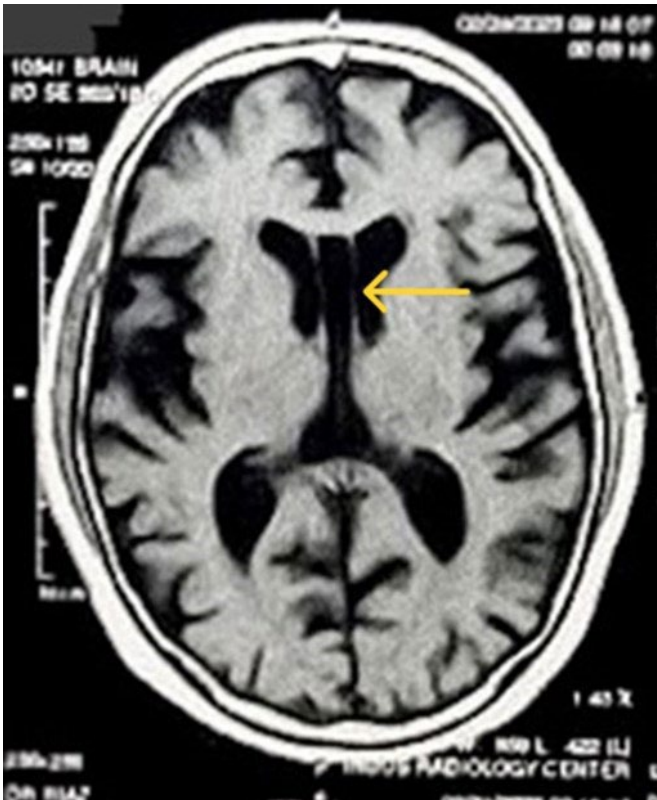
T1 weighted axial MRI visualizing CSP cyst (arrow).
